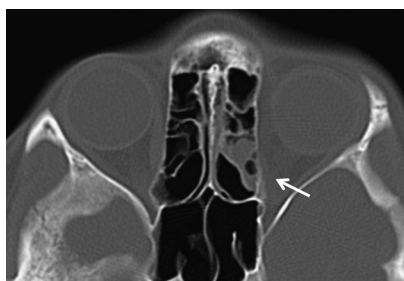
An axial CT image showing an isolated left orbit medial wall fracture (arrow).
